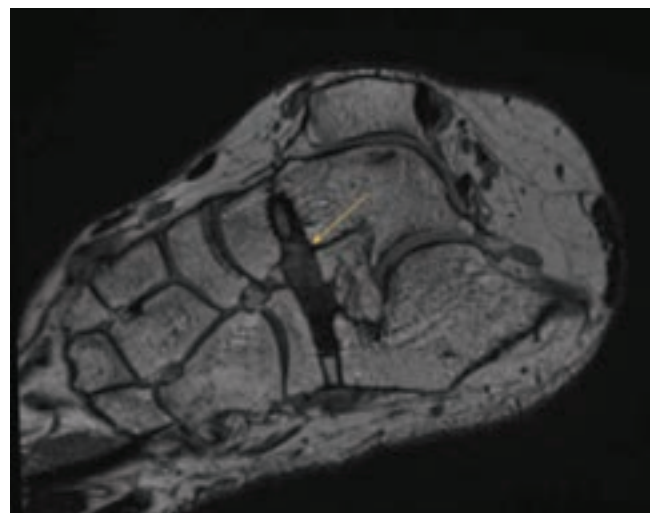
Volumetric Post-operative MRI images 30 months after surgery showing intact cervical ligament graft.
